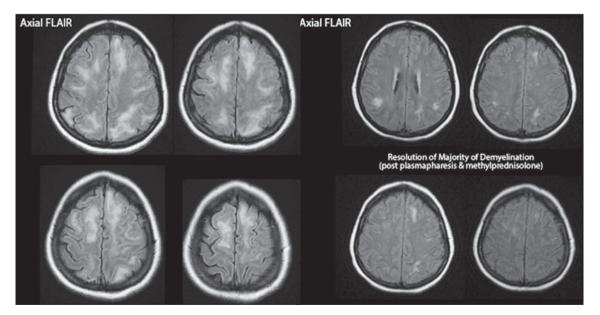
Axial FLAIR images in a child with ADEM before (Left) and after (Right) treatment with an interval of 4 weeks. The while matter lesions are diffuse and poorly demarcated and showed near-complete resolution with therapy.
